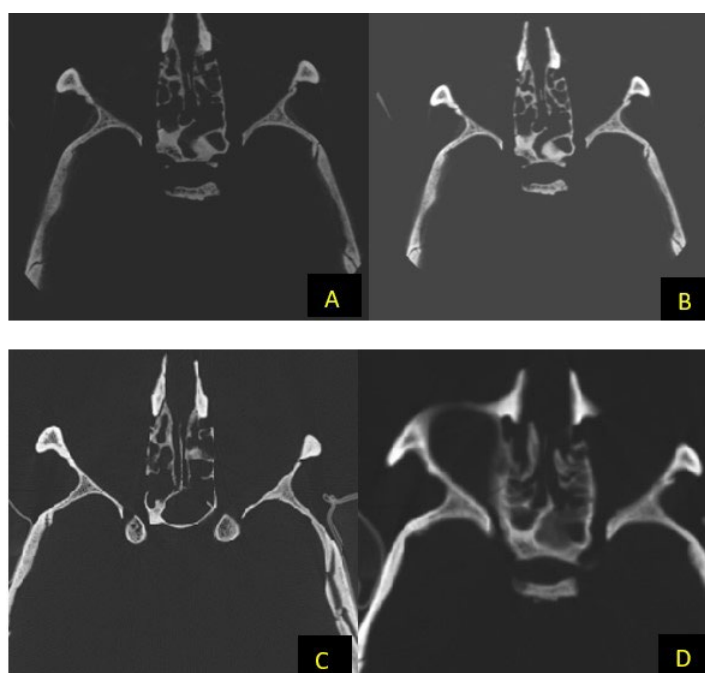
Axial sections; (A) high-resolution CBCT; (B) low-resolution CBCT, (C) high-resolution CT, (D) low-resolution CT
